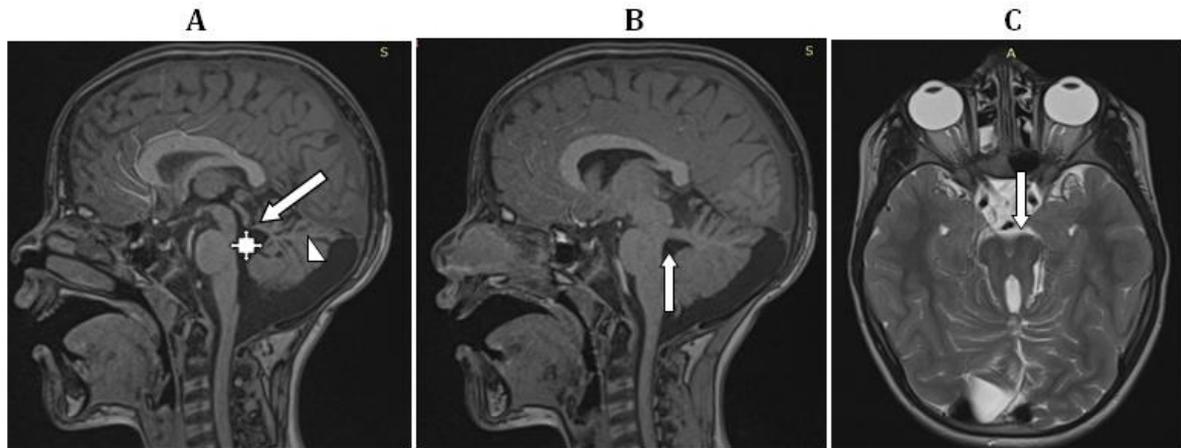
Brain MRI: A) T1 median sagittal section of the posterior cerebral fossa: moderate hypoplasia of the cerebellar vermis (arrowhead), dilation and opening of the V4 (asterisk), deepened interpeduncular fossa (arrow). B) T1 paramedian sagittal section of the posterior cerebral fossa showing thickening and horizontalization of the superior cerebellar peduncle (arrow). C) T2 axial section of the posterior cerebral fossa showing thickened and horizontal cerebellar peduncles with the characteristic "molar tooth" appearance (arrow)
